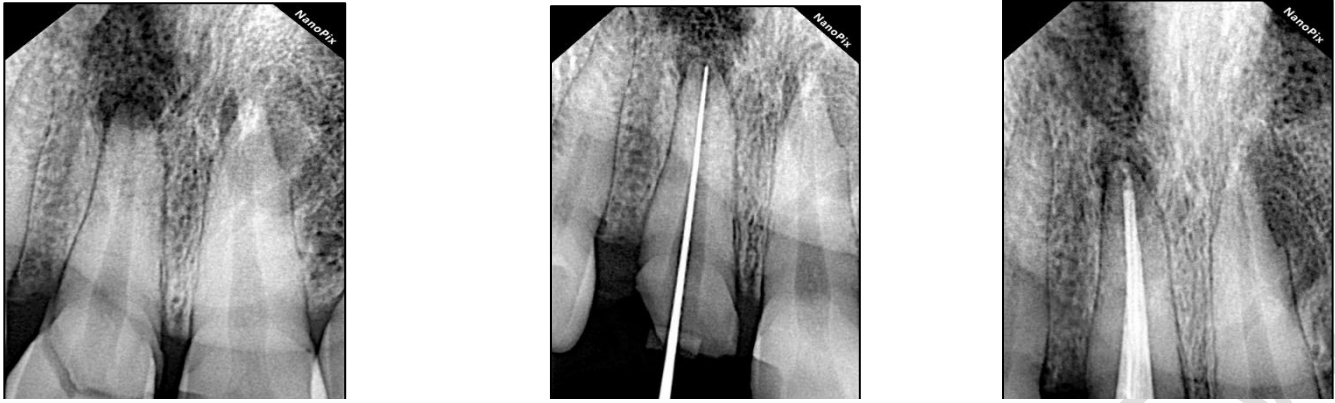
radiograph of a)pre operative; b) working length determination; c) obturation
